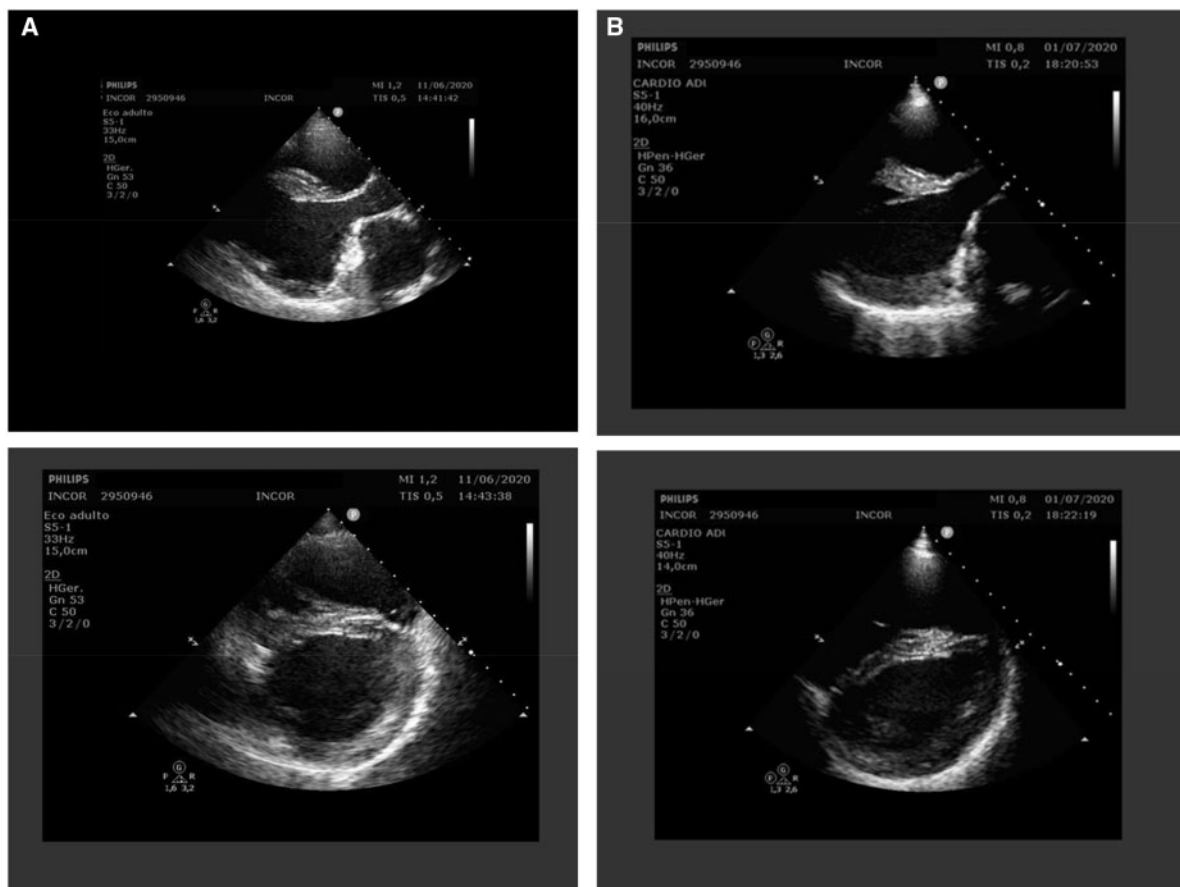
Transthoracic echocardiography two-dimensional images showed left ventricular diastolic diameter 58.0 mm and left ventricular ejection fraction 33.0%, right ventricle with slight dilation and moderate hypertrophy; left ventricle with marked dilation of significant systolic dysfunction with global hypokinesia (A); after 20 days of COVID-19, transthoracic echocardiography performed in an intensive care unit bed (limited window) showed no change in the measurements and left ventricular ejection fraction = 29%; (B) Simpson method.
